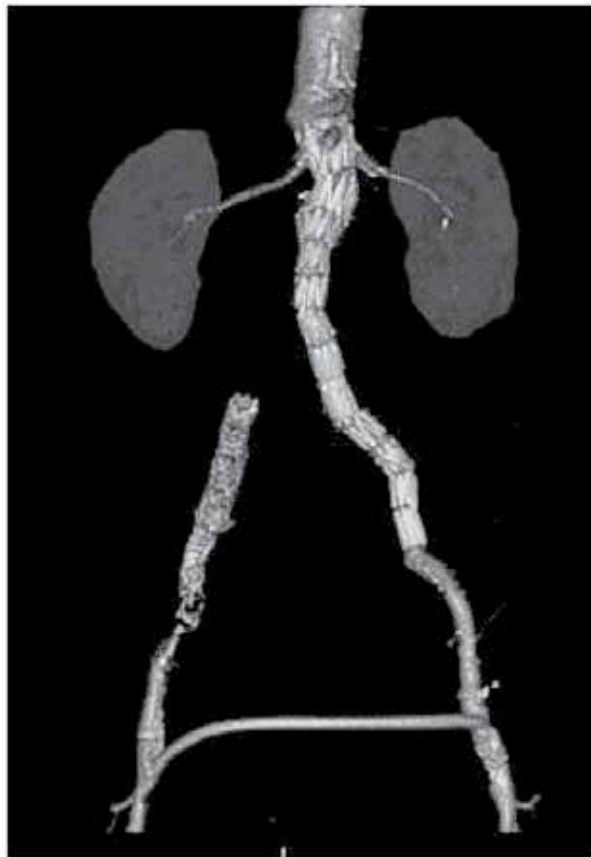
Post-operative angio-CT showing an aorto-unifemoral endograft with a femoro-femoral cross-over performed for a RAAA
